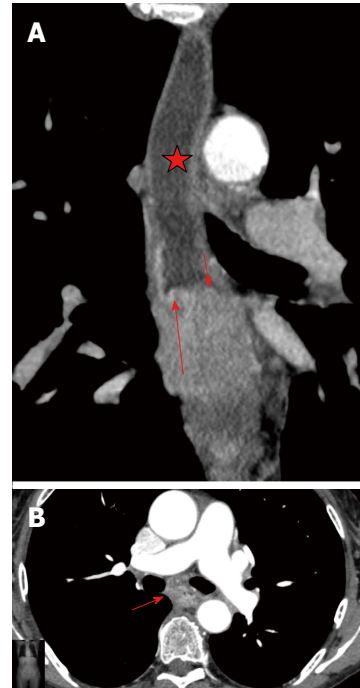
Esophageal cancer. A: Multidetector computed tomography (MDCT). Arterial phase. Coronal reconstruction of esophageal cancer. Tuberosus upper and lower boundaries of stenosis (short arrow); rupture of the mucous membrane at the upper boundary of stenosis (long arrow); cup-shaped suprastenotic dilatation (star); B: MDCT. Arterial phase. Axial CT scan of esophageal cancer. Eccentric esophageal wall thickening without mucous membrane visualization in stenosis (arrow).
